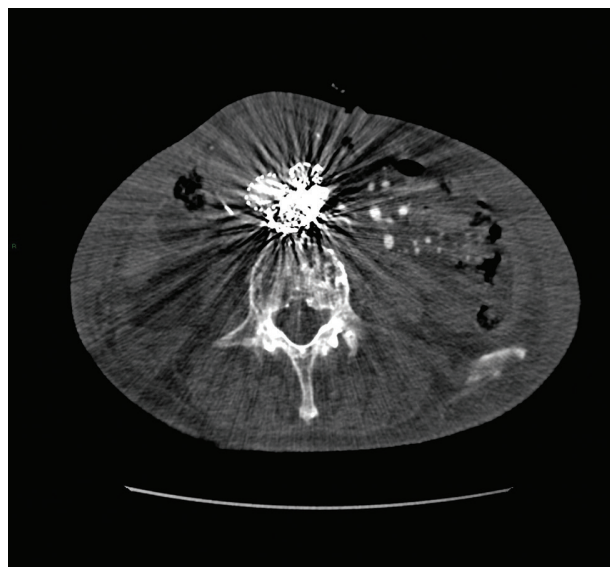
A CTA at 3-month follow-up showed no endoleak and a stable aneurysmal sac.
